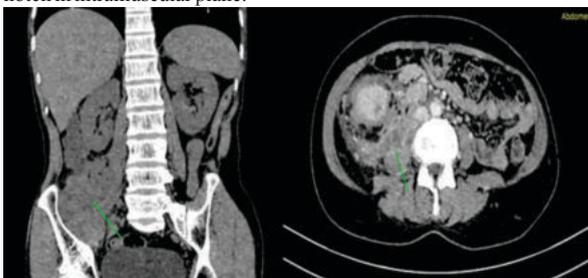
MRI & CT sections showing bulky right psoas
